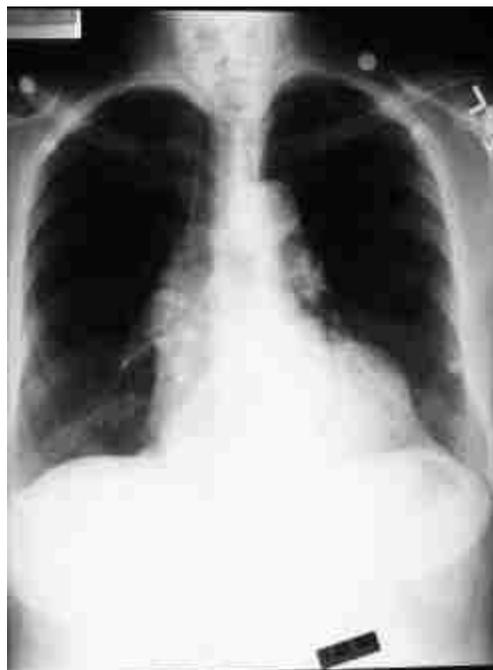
Chest radiograph following aneurysm surgery
